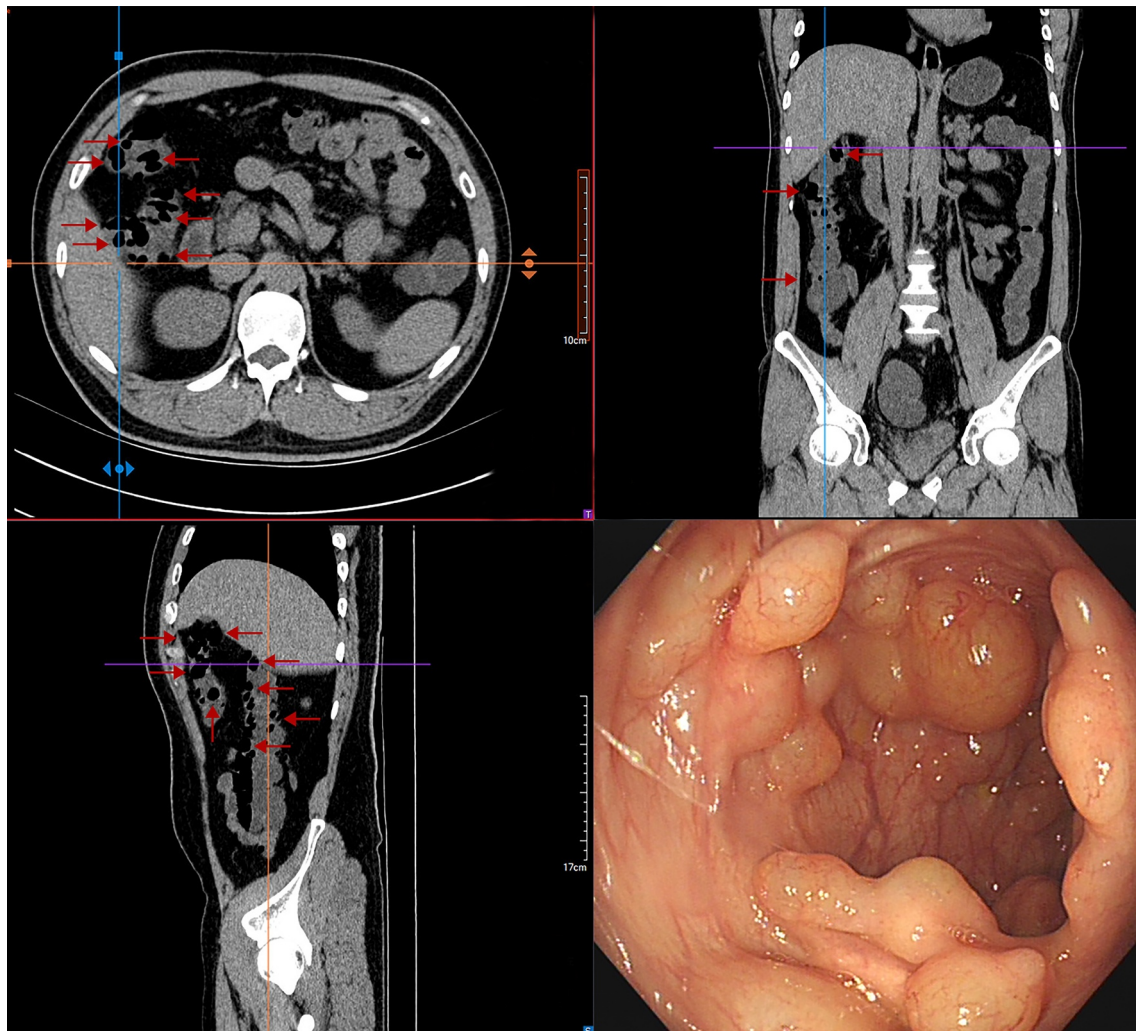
Axial, coronal, and sagittal views of a CT scan of the hepatic flexure of the ascending colon, along with a colonoscopy image from the same location, indicate a PCI intestinalis.
